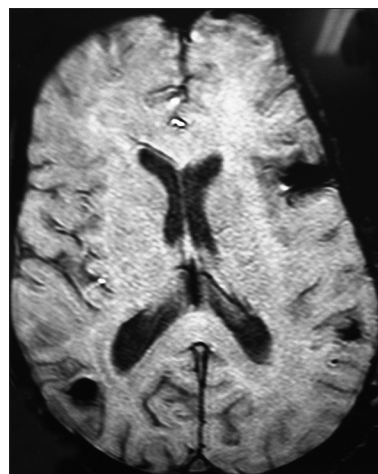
Magnetic resonance imaging brain susceptibility weighted imaging axial sections showing numerous other lesions on either side
